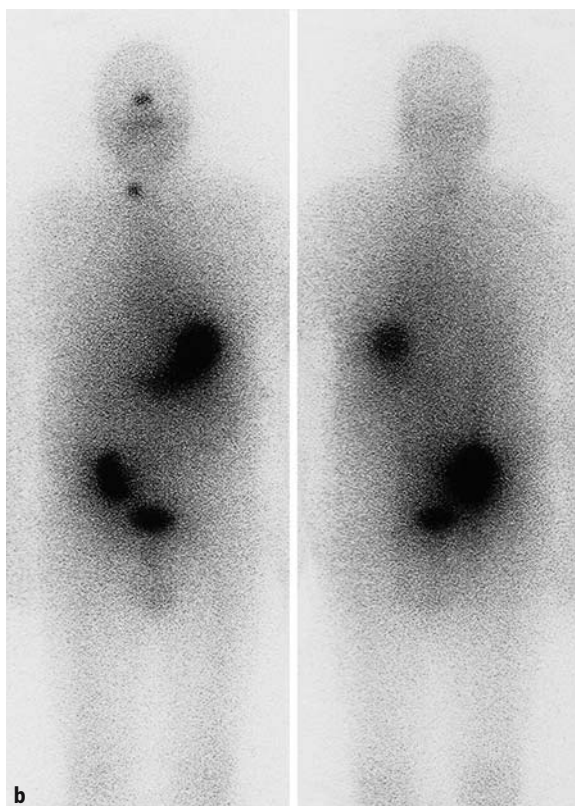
a, b. Sixty-two-year-old patient with follicular thyroid cancer pT2N0M1 (right os ilium). The first radioiodine therapy (3.7 GBq ^{131}I) and subtotal resection of the osseous metastasis had already been performed. a ^{123}I whole-body scintigraphy (185 MBq ^{123}I) 3 months later, and b ^{131}I whole-body scintigraphy (7.4 GBq ^{131}I) demonstrated the osseous metastasis in the right pelvis and thyroid remnant on the right side. Misinterpretation as residual activity in the large bowel must be avoided. Subsequently, the patient underwent external radiation therapy
